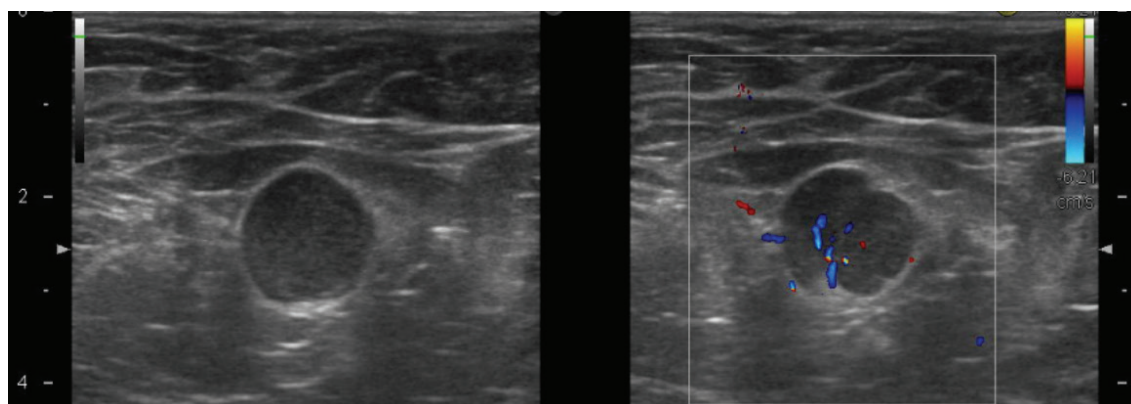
Ultrasound images show axillary lymph nodes enlargement, with a thick cortex
